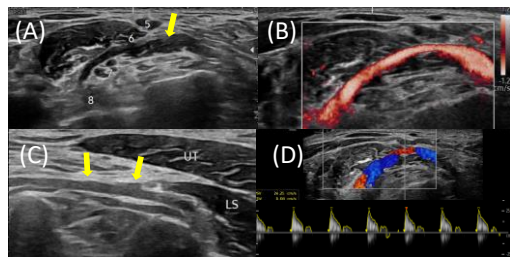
(A)–(D) Sonography of left brachial plexus and its nearby traversing dorsal scapular artery. (A, B) Brachial plexus trunk (5, 6, 7, 8 each indicate C5, 6, 7, 8 roots) and nearby traversing vessel (arrow) which is assumed to be dorsal scapular artery. (C) The brachial traversing vessel (arrow) supplies levator scapulae muscle (LS) and can be inferred as dorsal scapular artery. (D) M mode confirms brachial plexus crossing vessel has pulsation and is an artery.
